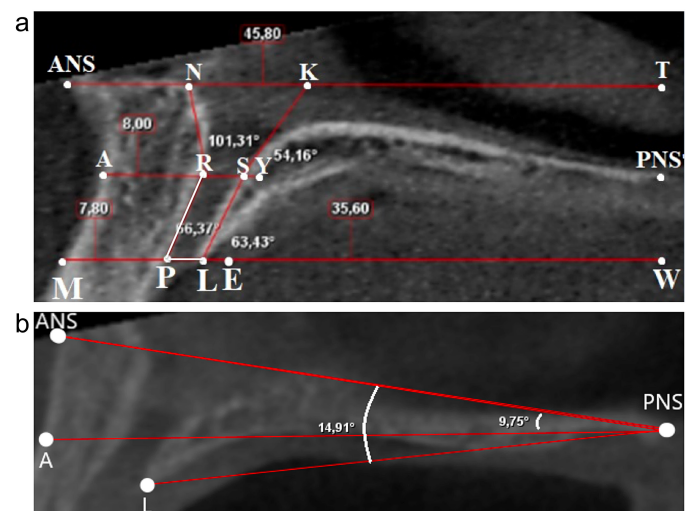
CBCT measurements of 3 different angles between specific points in midsagittal section of maxilla. (a). Note the white-colored RPL angle (RPL angle revealed a significant difference in osteoporotic patients) (b). Three different angles between PNS and the specific points. CBCT, cone-beam computed tomography; PNS, posterior nasal spine.
